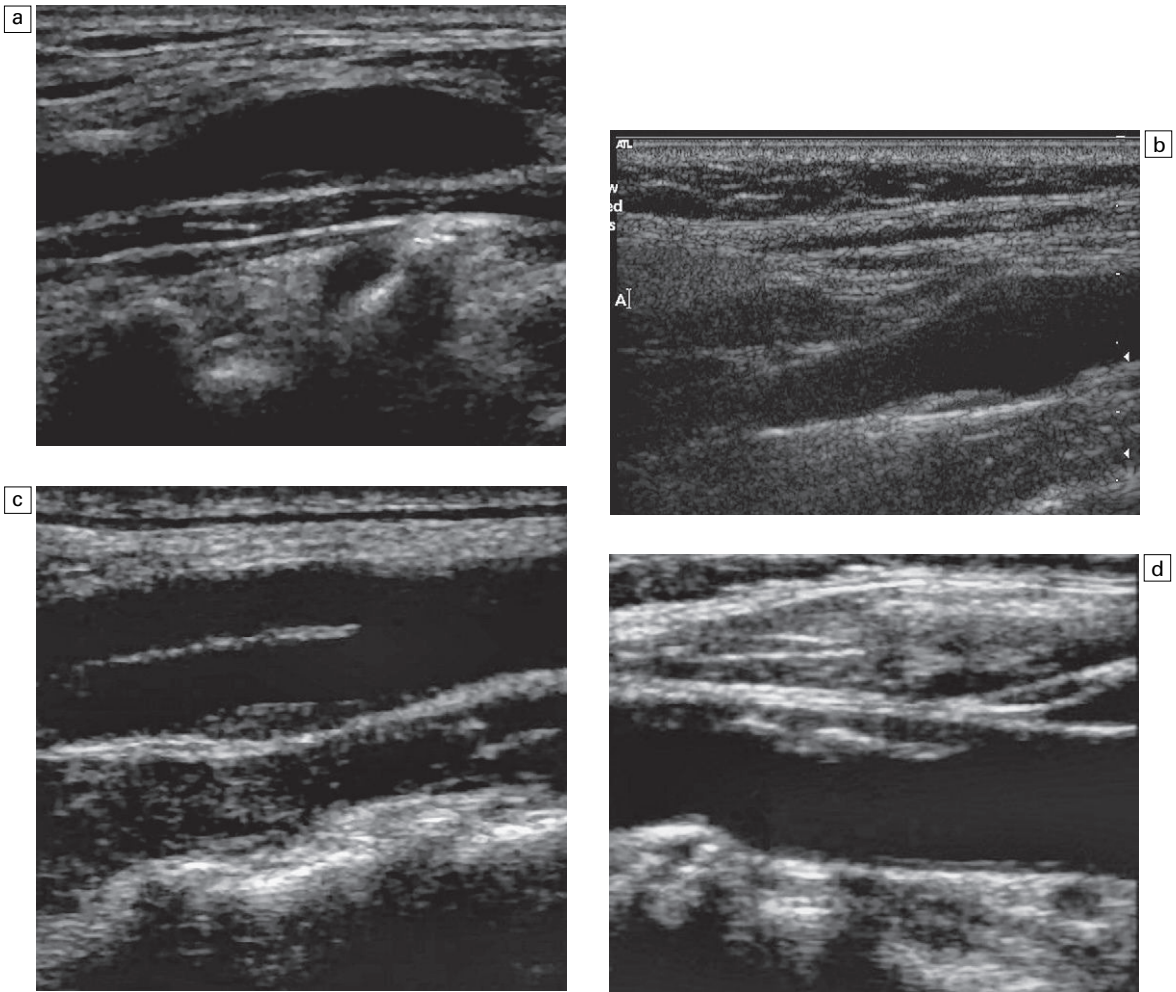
Different types of plaque seen on ultrasound. (a) Type 1, dominantly echolucent with a thin echogenic cap. (b) Type 2, substantially echolucent lesions with small areas of echogenicity. (c) Type 3, dominantly echogenic lesions with small areas of echolucency of <25%. (d) Type 4, uniformly echogenic lesions.
